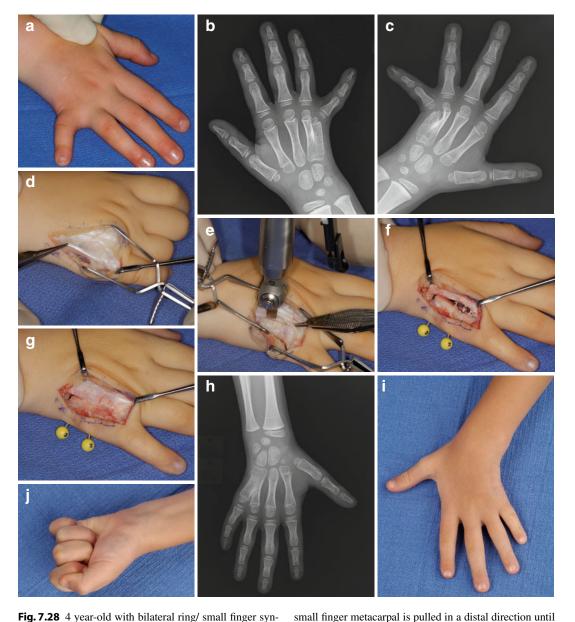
4 year-old with bilateral ring/ small finger synostosis (Courtesy of Shriners Hospital for Children, Philadelphia). (a) Right hand with small finger abducted. (b) Right hand x-ray reveals extensive ring/ small finger synostosis. (c) Left hand x-ray with similar synostosis. (d) Dorsal approach and isolation of the extensor apparatus. (e) Synostosis divided with an oscillating saw. (f) The
